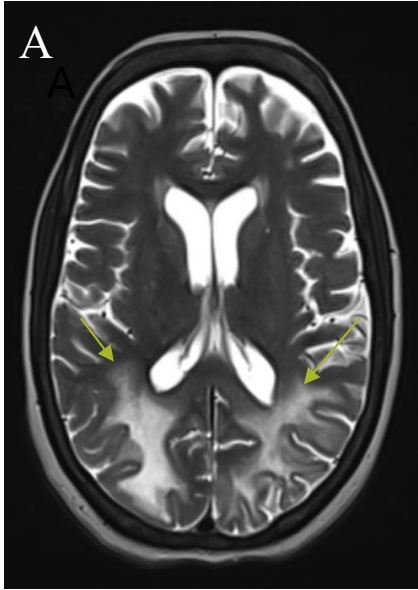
MRI Brain (at the time of presentation) axial T2 weighted sequence (A) showing hyperintensity in the periventricular deep white matter of bilateral parietal & right frontal lobes. No enhancement seen on axial postcontrast T1-weighted sequence (B).
